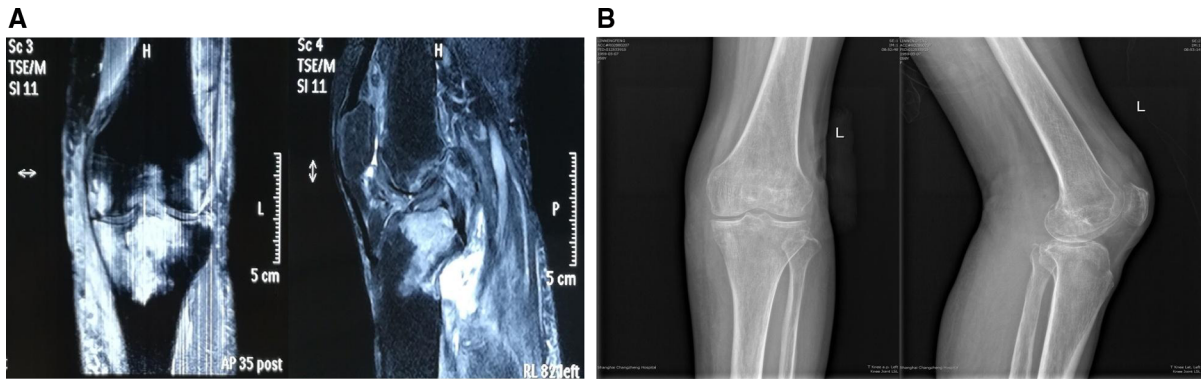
Radiographs of the knee revealing extensive destruction and bone marrow edema of the femur and tibia, osteoarthritis, popliteal cyst, joint cavity effusion. a Sagittal and coronal images of MRI. b X-rays of the knee
